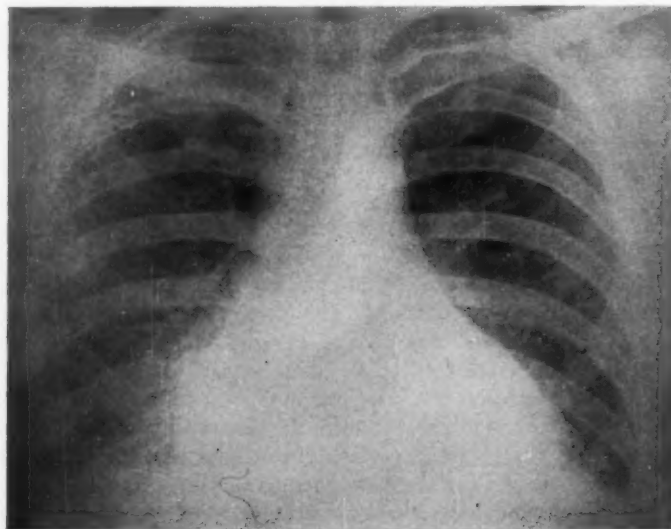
Chest roentgenogram on day of second hospital admission shows further increase in the cardiac silhouette with blunting of both costophrenic angles.
